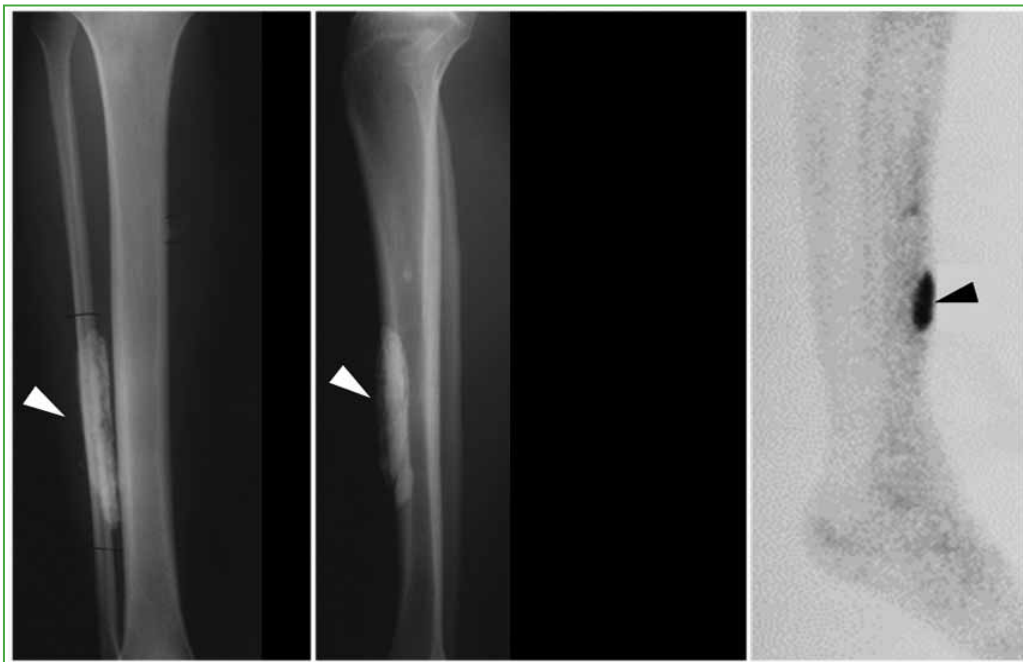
Myositis ossificans in the mature phase. Leg radiographs show tibial calcification adjacent to the shaft and bone scan uptake.
